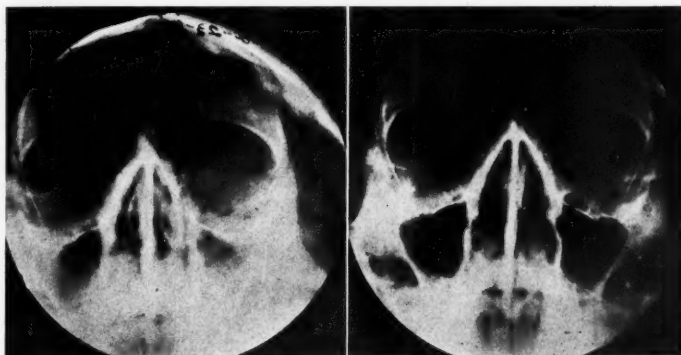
Case 2. Radiograph showing the antra at time of treatment. Symptoms date back two years.
